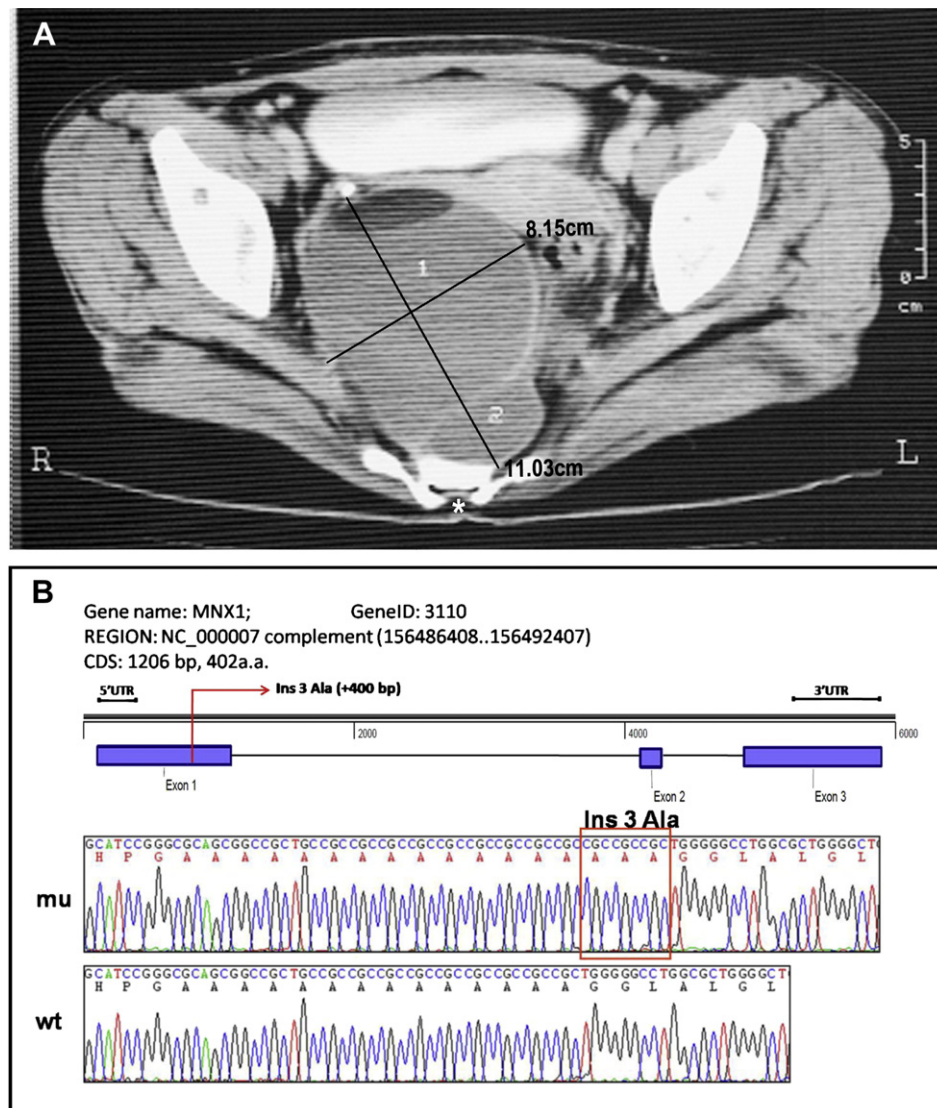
(A) Computed tomography scan in a 26-year-old woman showed a presacral tumor measuring about 11.03×8.15 cm with two components and spina bifida (white star). (B) Genetic analysis of *MNX1* in this patient disclosed three CGC (alanine) repeats in exon 1.
